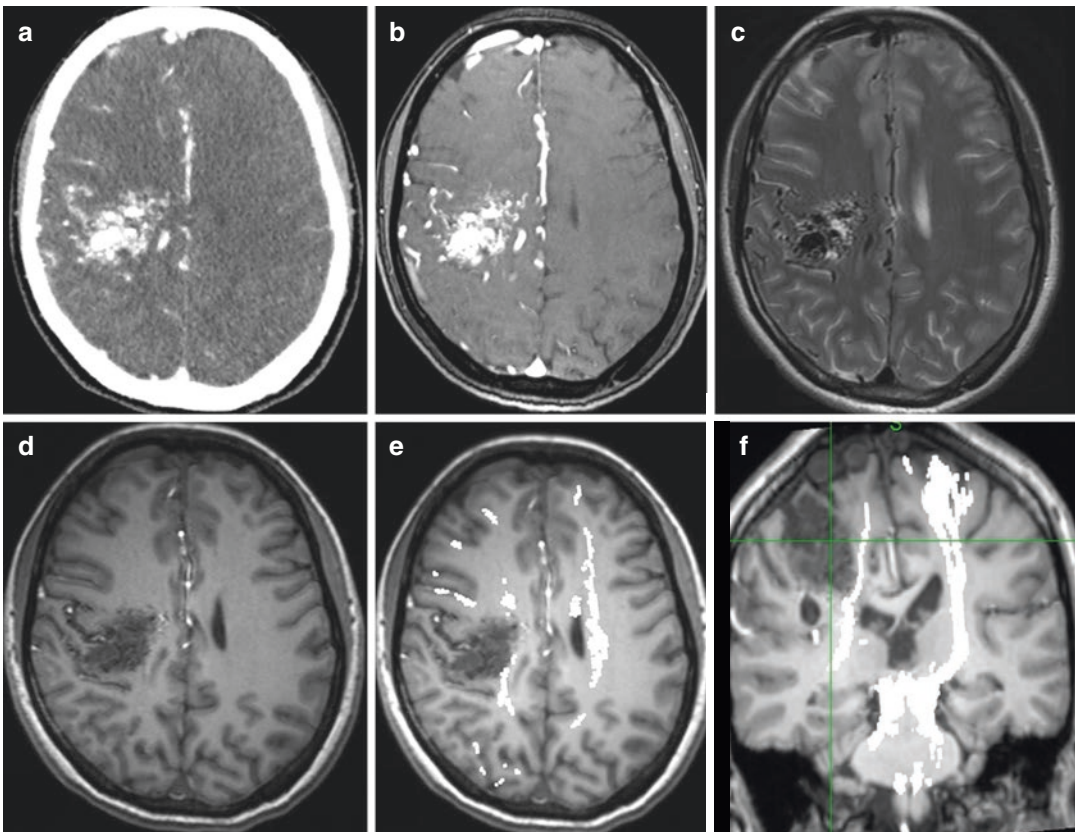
Acquired axial CT and anatomical MRI slices from the AVM patient. DTI fused with the anatomical MRI data showing corticospinal tract in corresponding axial, coronal, MRI plane. (a) Contrast-enhanced CT. (b)
